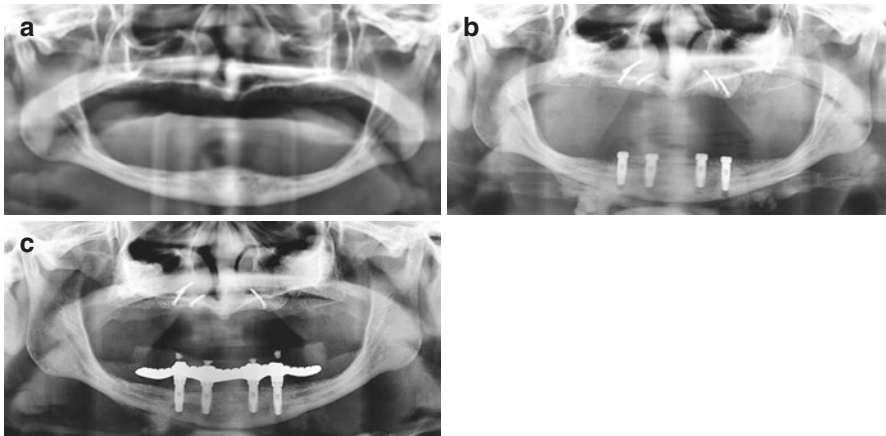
(a) Preoperative radiograph. (b) Implants placed with the tent-pole technique with autogenous particulate anterior iliac crest bone graft and biomaterial. (c) Partial vertical resorption of the graft
